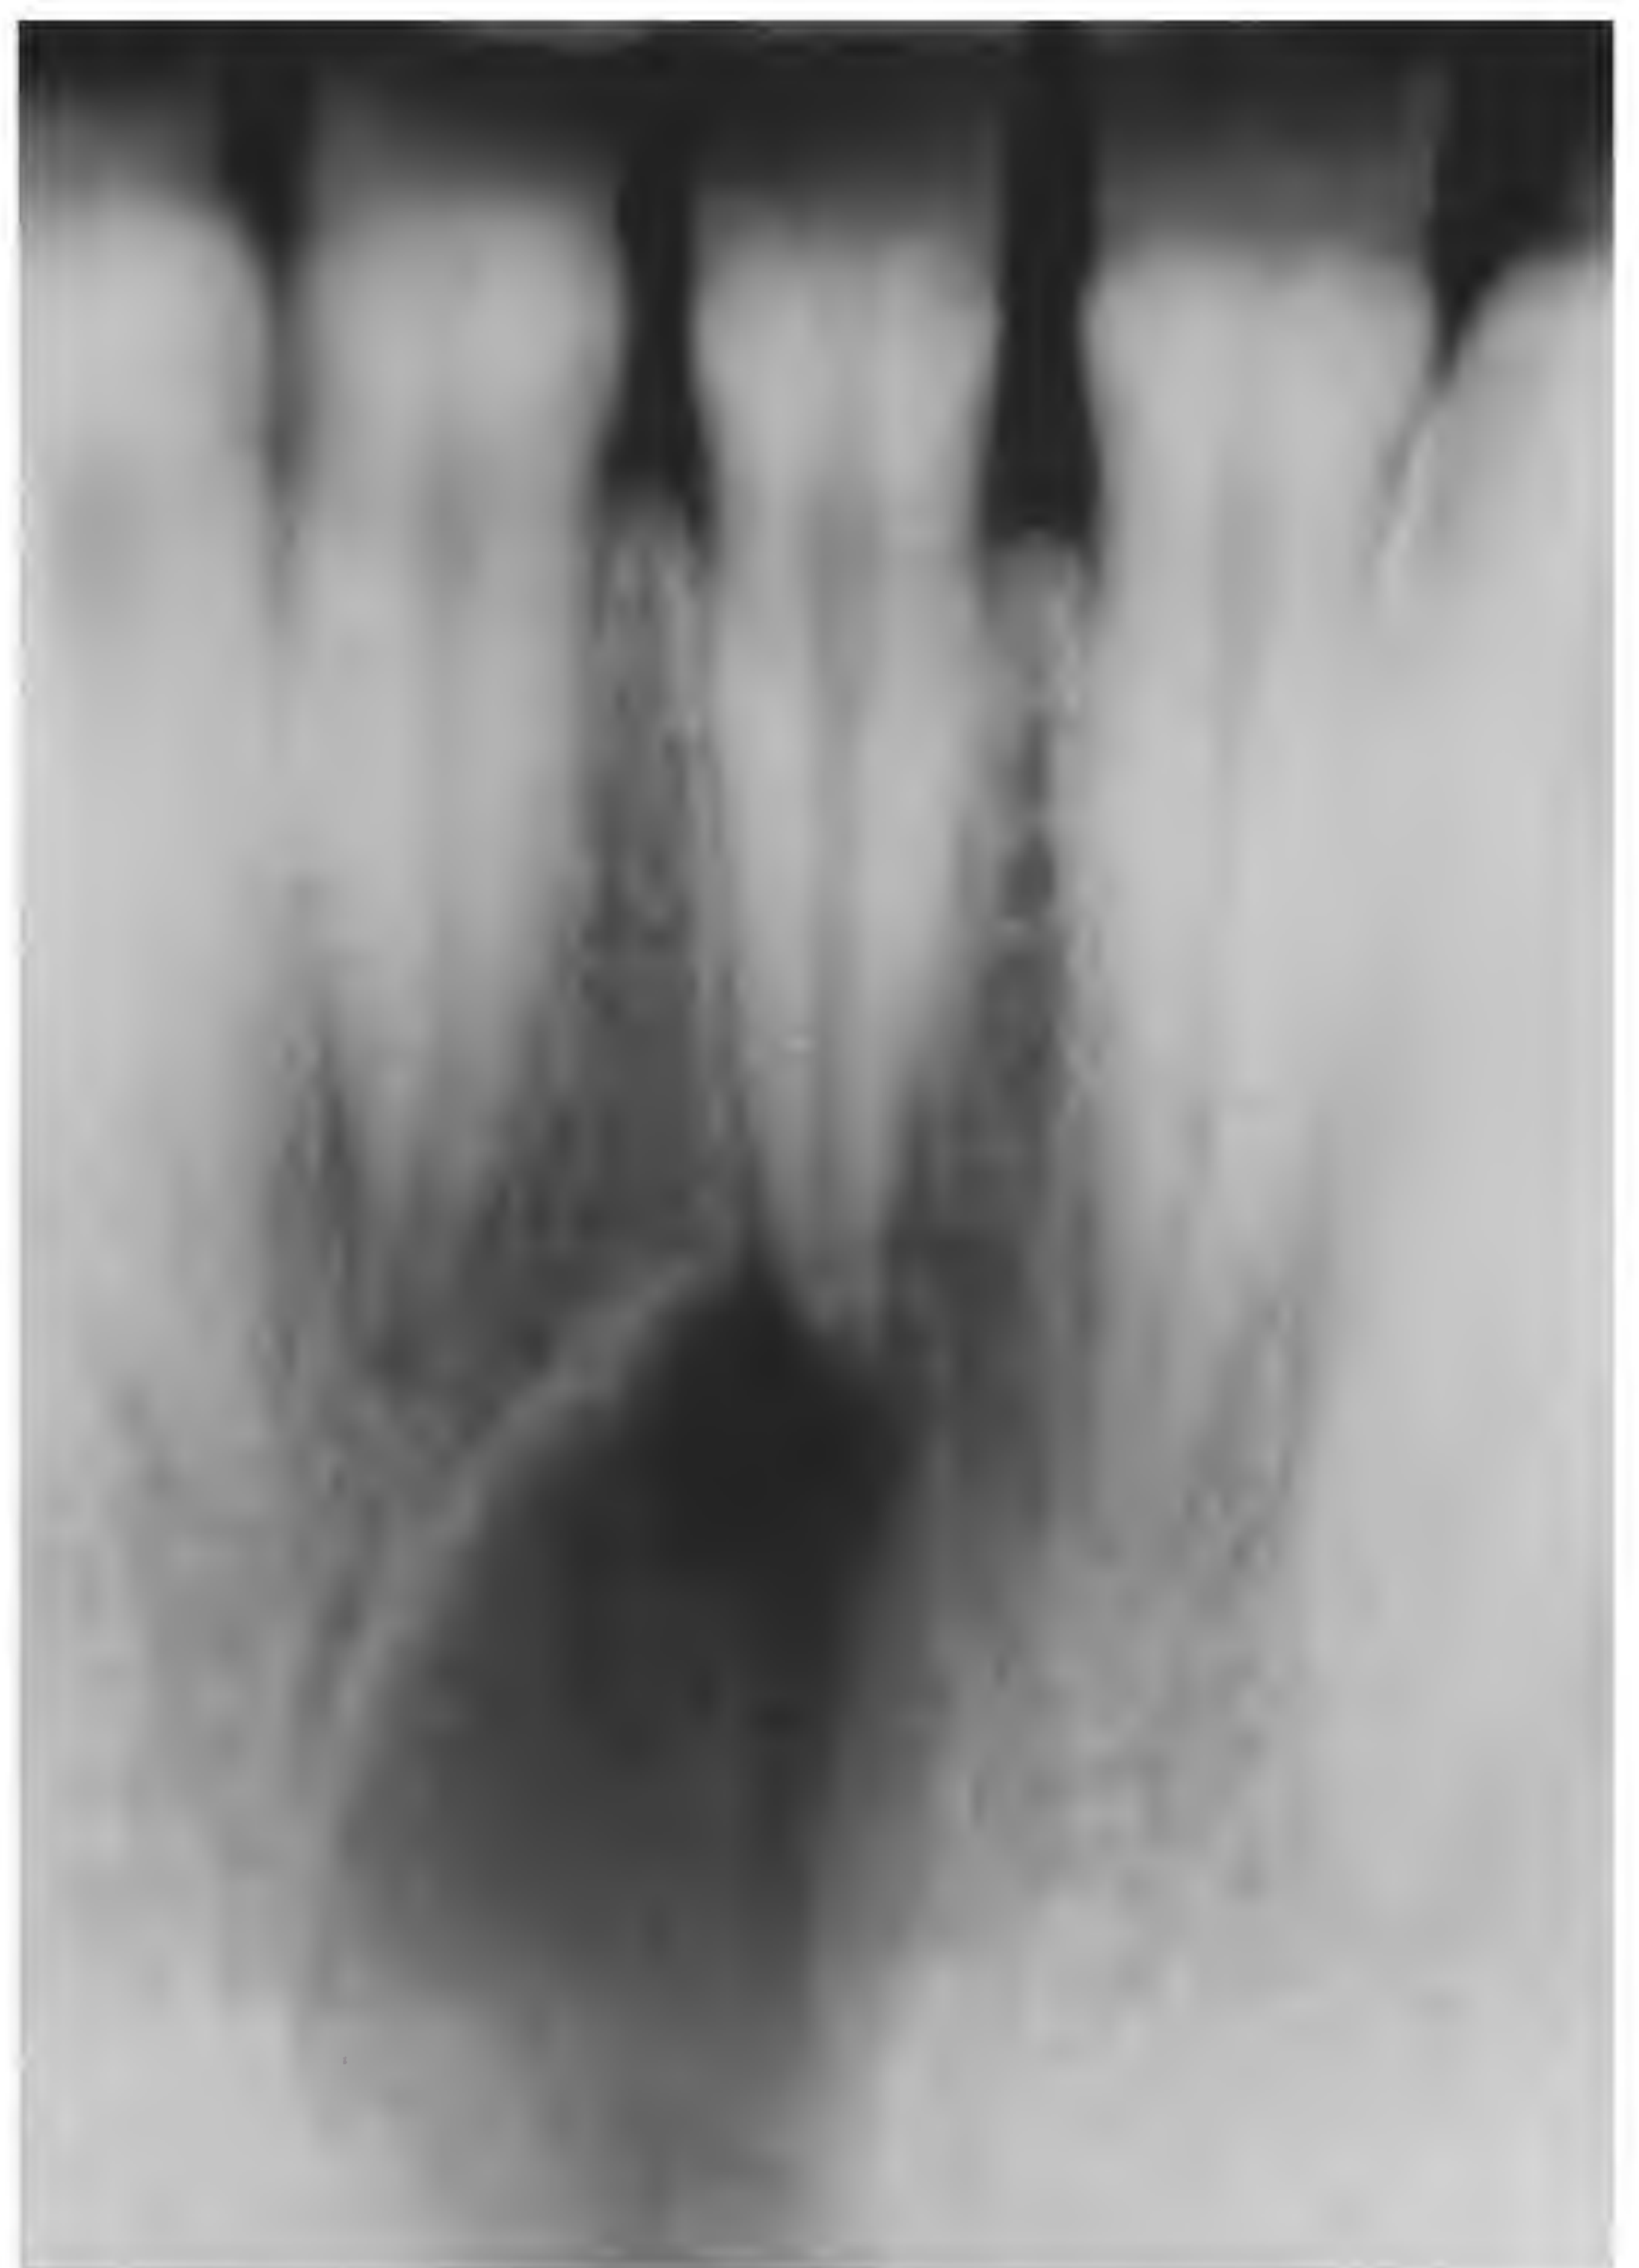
Periapical cyst.
